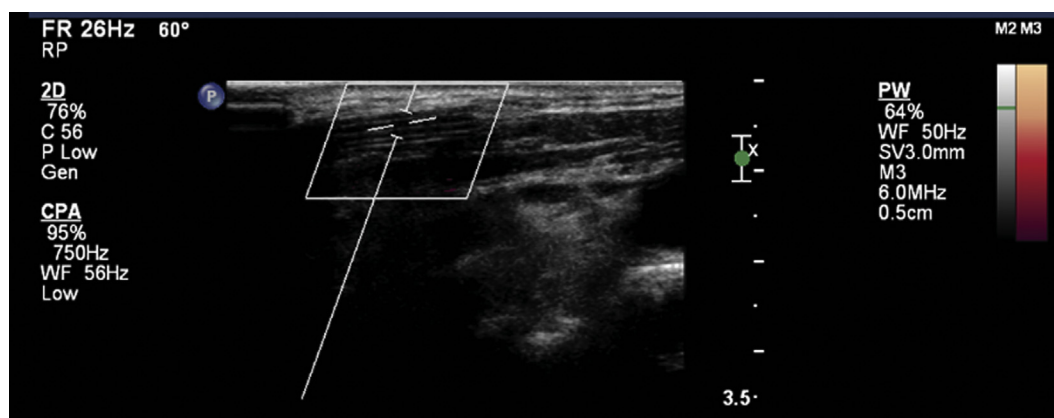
Shunt catheter in neck visualized with ultrasound.
